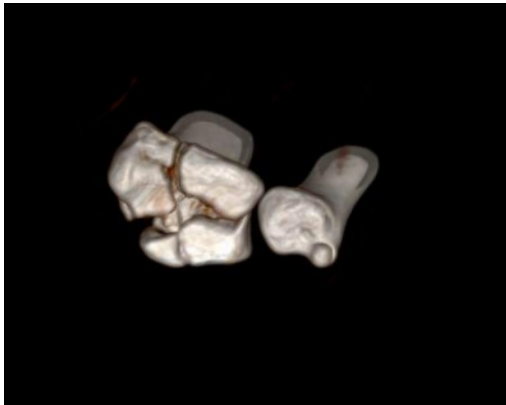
3D Reconstructed CT of the distal radius and ulna.
